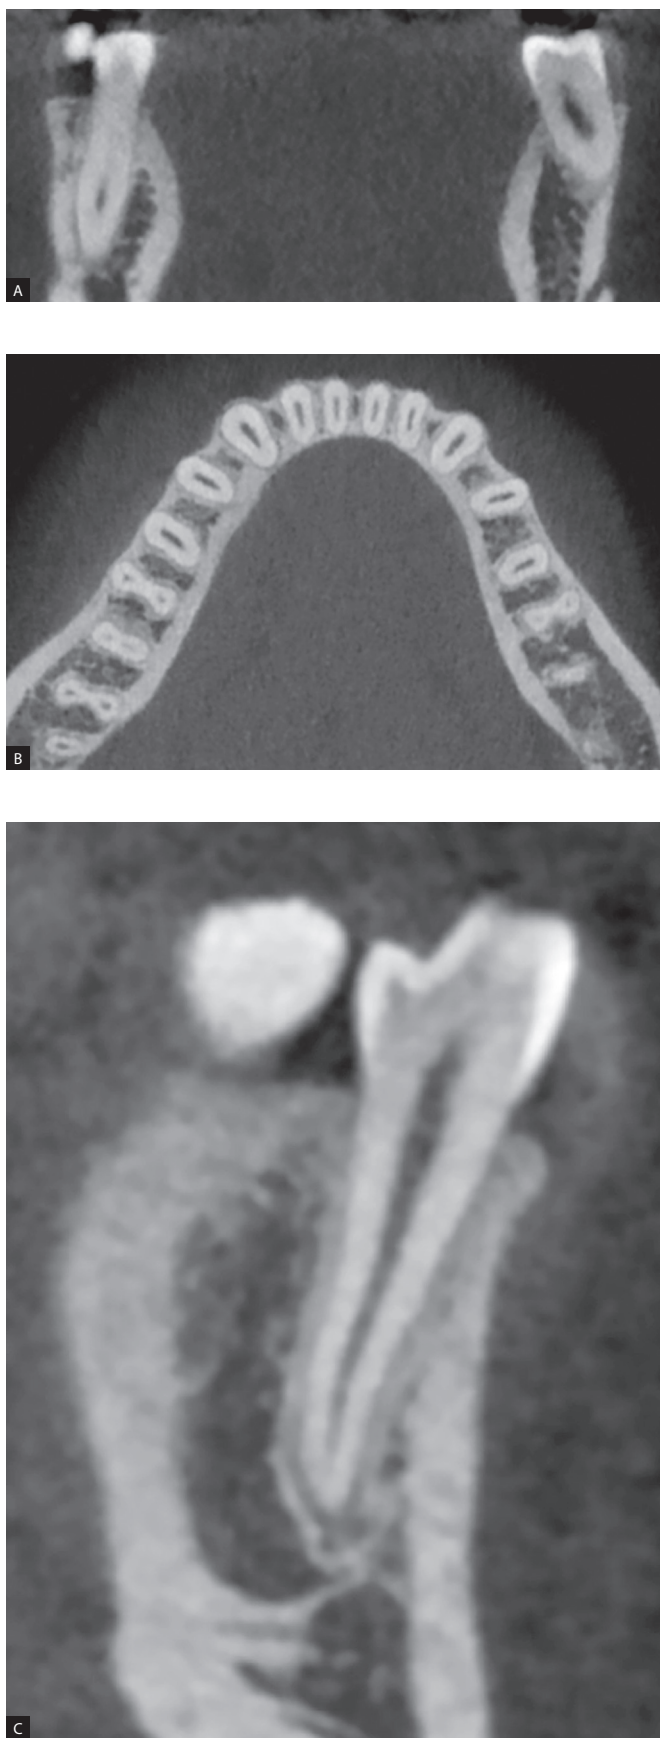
Cone-beam computed tomography image: A) Crown section; B) Axial section; C) Sagittal section.
